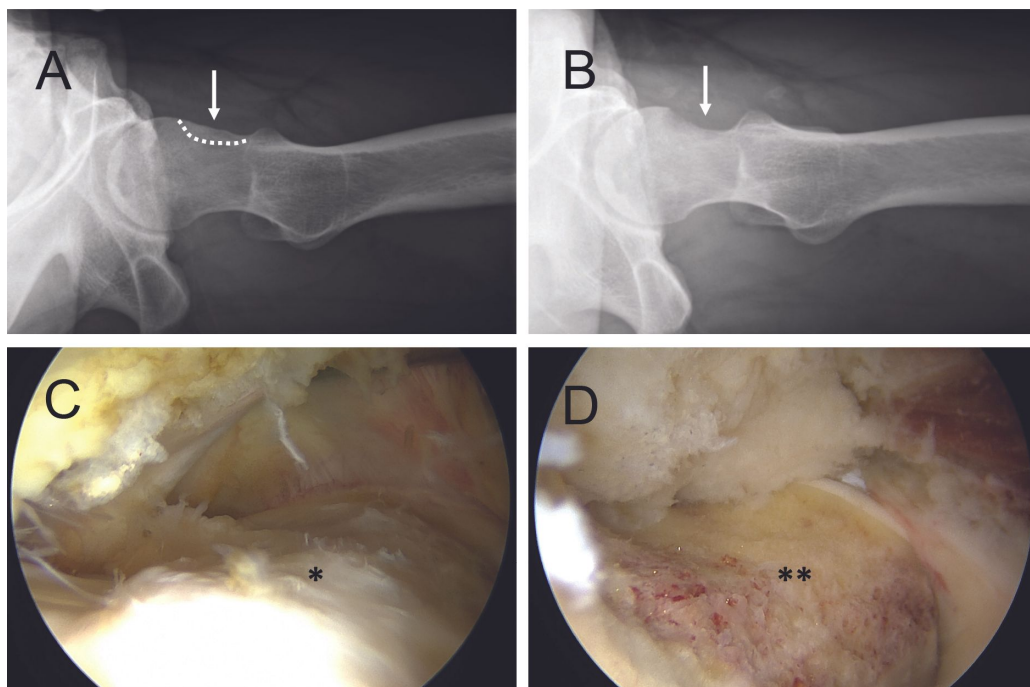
Hip arthroscopy. On the preoperative axial X-ray (A), the cam effect (white arrow) is seen. On the postoperative axial radiograph (B), the filling of the head-neck junction has been resected arthroscopically. The cam effect (*) is observed during arthroscopy (C) and a femoral osteochondroplasty (D) is performed with a burr to correct the neck/head junction ().
